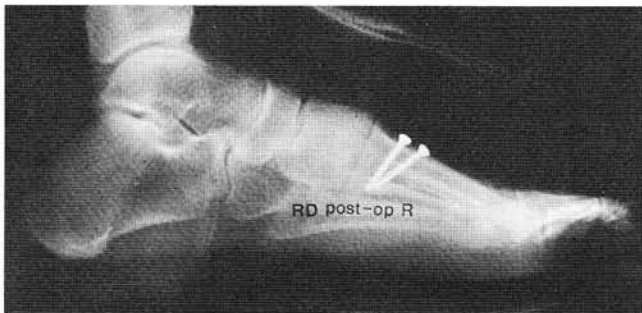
This lateral radiograph demonstrates that the proximal screw is perpendicular to the horizontal plane (anchor screw), while the distal screw is perpendicular to the osteotomy (compression screw).
